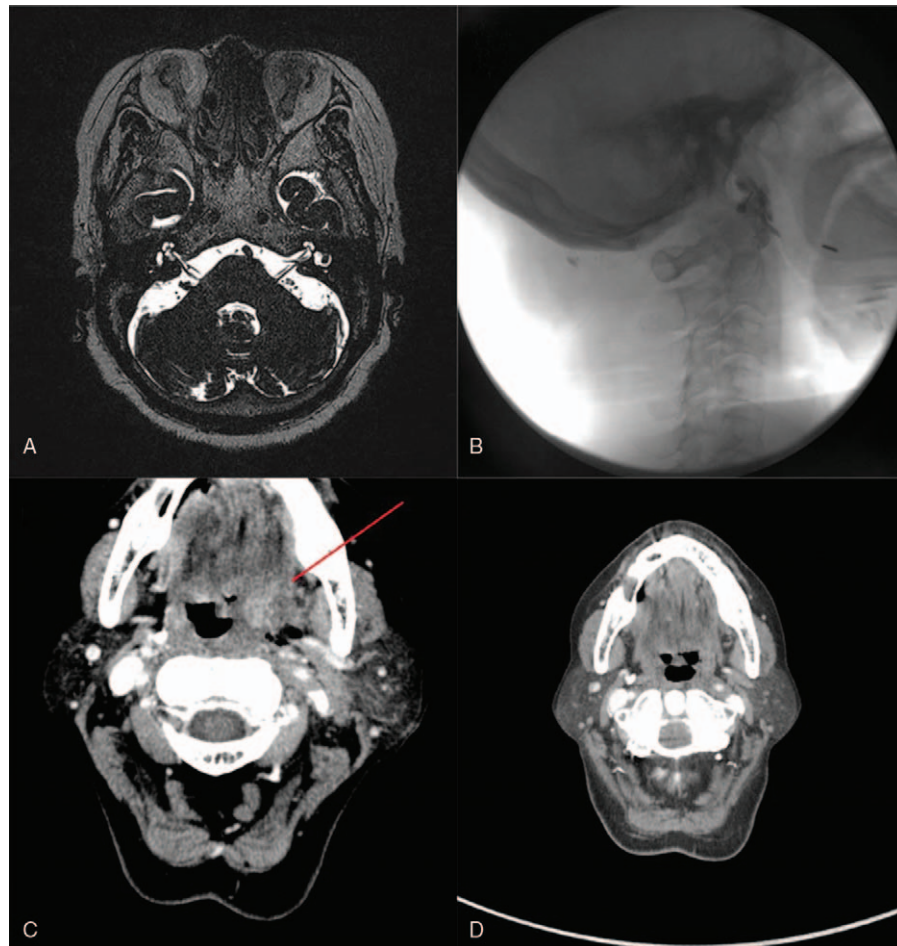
(A) There are non-specific lesions at the left glossopharyngeal nerve in brain magnetic resonance imaging. (B) Peristyloid approach was used while we performed glossopharyngeal nerve block, neurolysis, and pulsed radiofrequency neuromodulation. (C) There are chronic inflammation and enlarged lymph nodes in her neck. (D) CT image shows resolved state of chronic inflammation and enlarged lymph node in her neck. CT = computed tomography.
